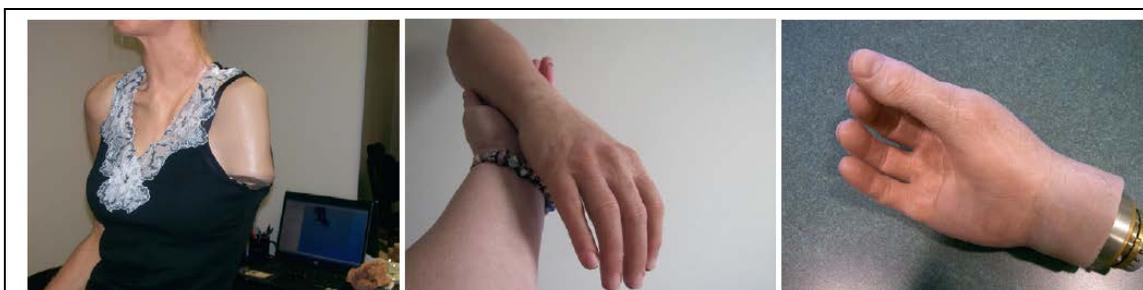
Passive prostheses and restorations (A, Courtesy CPS, Branford, CT; B, Courtesy Alternative Prosthetics).
